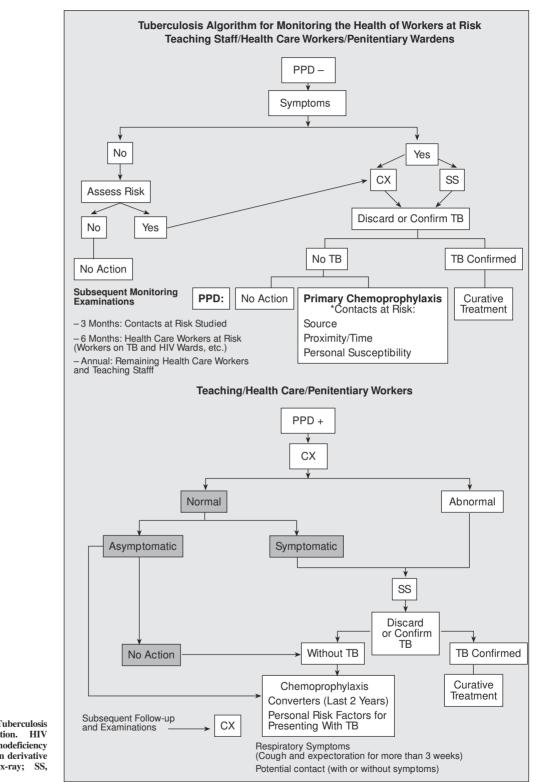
Decision tree for Tuberculosis (TB) Contact Investigation. HIV indicates human immunodeficiency virus; PPD, purified protein derivative tuberculin; CX, chest x-ray; SS, sputum-smear.
